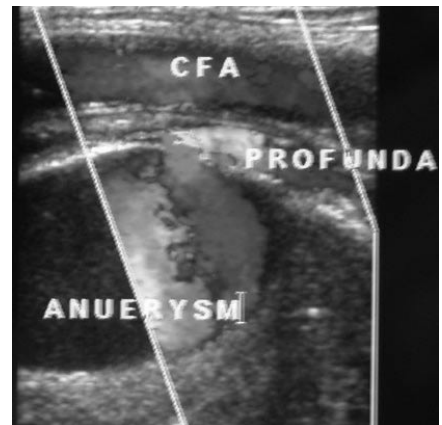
Ultrasound scan confirming diagnosis of profunda femoris pseudoaneurysm.
